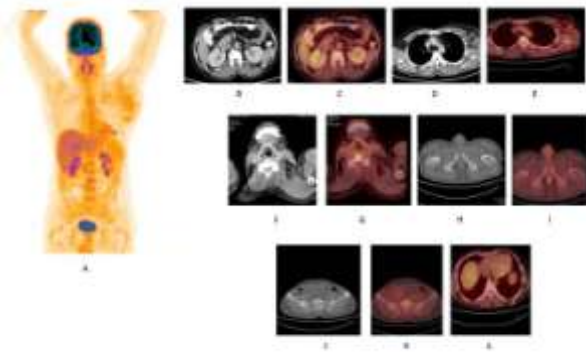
[A]. Maximum intensity projection image showing physiological FDG biodistribution. [B,C]: CT and fused PET/CT images showing no morphological and metabolic abnormality at the treated site in colon. CT and fused PET CT showing Left level III cervical lymph nodes showing no increased FDG concentration. [D,E]: CT and fused PET/CT images showing enlarged Left axillary lymph nodes with increased FDG concentration. [F,G]: Non-FDG avid Lt cervical lymph nodes . [H,I]: CT and fused PET/CT images showing Non-FDG avid sclerotic focus in Rt. femur neck.[J,K]: CT and Fused PET/CT images showing lytic lesion in Rt. Ilium. [L]: fused PET/CT image showing small soft tissue density lesion in the sub cutaneous plane in Left lower chest wall posteriorly with increased FDG concentration.
